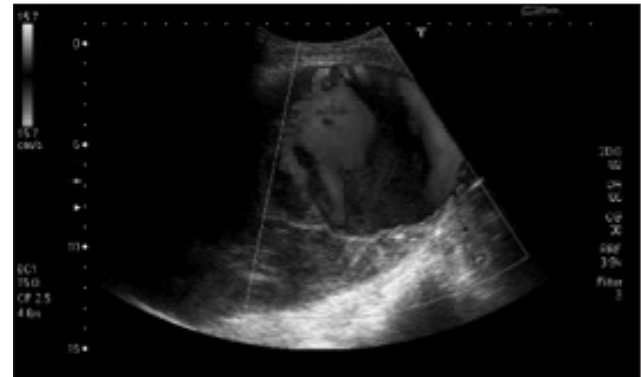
Doppler ultrasonography showing giant vein aneurysm containing a thrombus.
